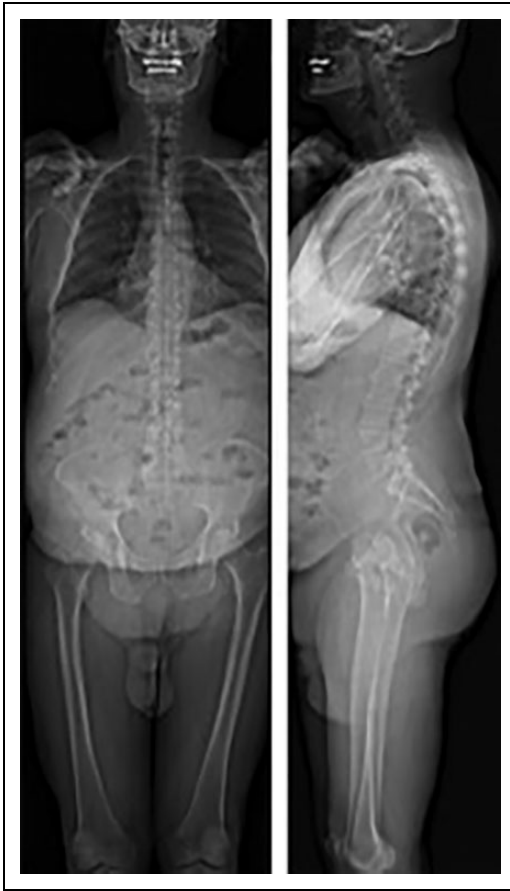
Baseline radiograph case example of a 70-year-old patient with degenerative spondylolisthesis and severe lumbar stenosis. The patient presented with a Physical Function score of 24.7, Pain Intensity score of 68.3, Pain Interference score of 71.6, and overall ODI score of 78. ODI, Oswestry Disability Index; PROMIS, Patient-Reported Outcomes Measurement Information System.
